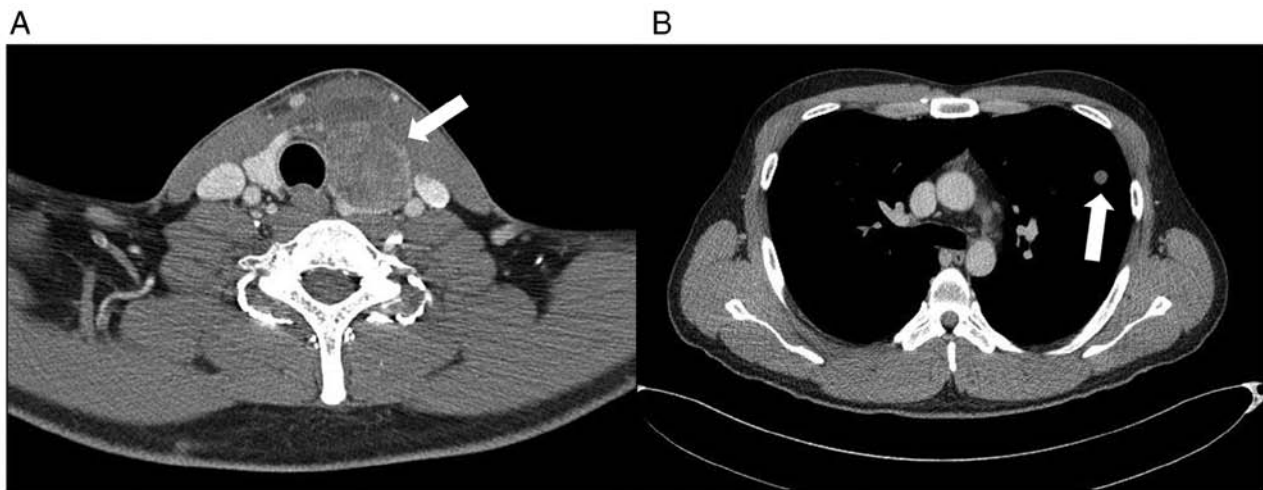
(A) Computed tomography scan which showed a 4.0 cm sized tumor in the left lobe of the thyroid gland. The border of tumor indicated infiltration into adjacent tissue. (B) Computed tomography scan which showed a lung nodule in the upper, left lobe.
